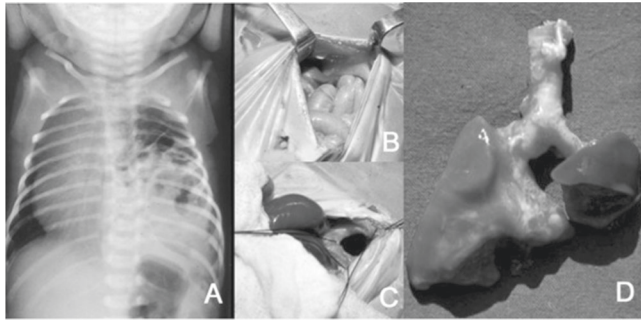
CDH infant with impaired lung development. a Chest X-ray of an infant with congenital diaphragmatic hernia. Intraoperative image of the diaphragmatic defect with b herniated bowel and c subsequent reduction back into the abdomen. d Gross image of severe ipsilateral lung hypoplasia. Images reprinted from Tovar et al.¹²⁷ under the terms of the Creative Commons CC BY license.
